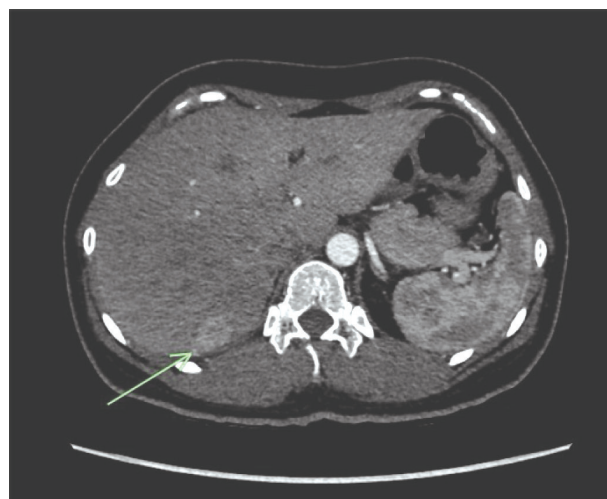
Contrast CT scan shows the mass size of 2.3 cm at segment VII in the arterial phase.
